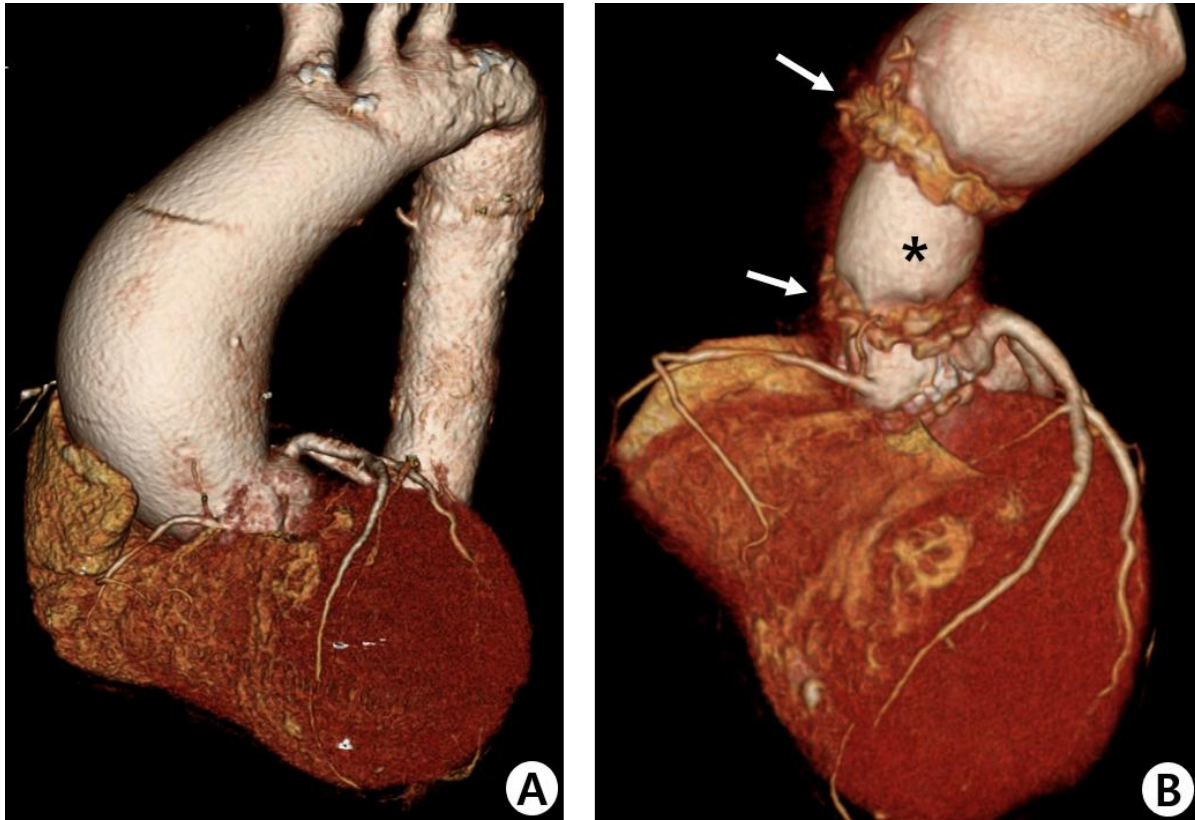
These images show the comparison of (A) pre- and (B) postoperative three-dimensional computed tomography in patient 2. The maximal size of the ascending aorta was decreased significantly from 59 mm to 32 mm (artificial graft (Astro-mark) was patent). The anastomotic sites are shown by an arrow.
